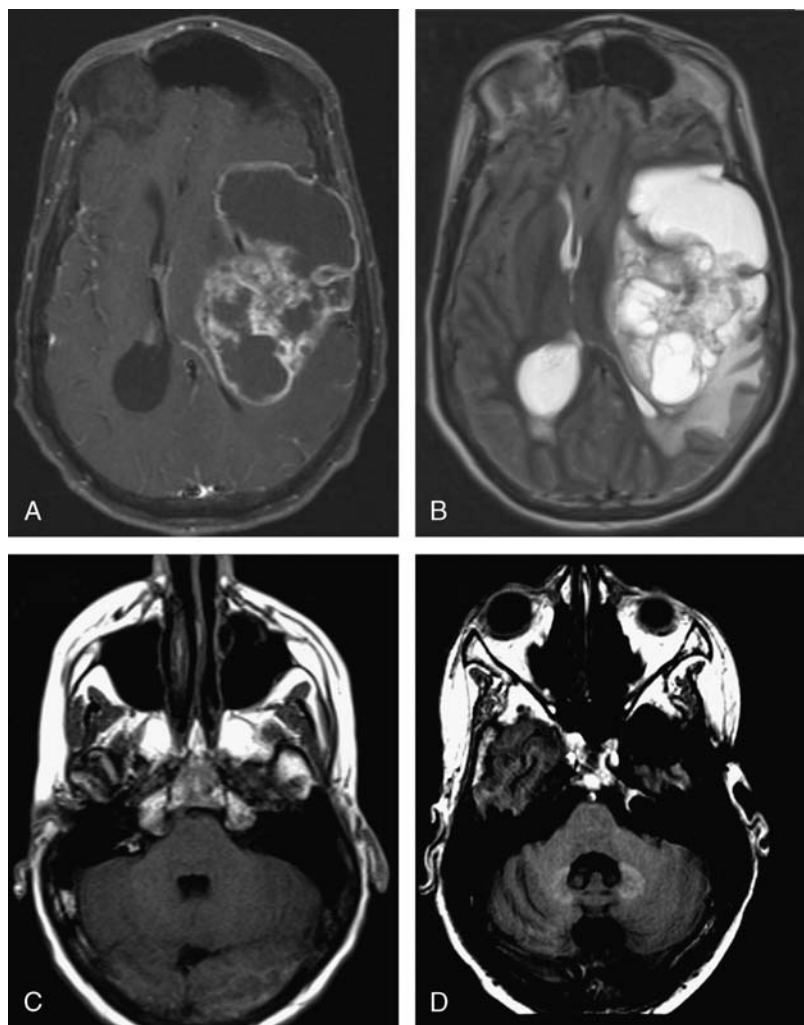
Axial postcontrast, fat-saturated, T1-weighted image (A) and axial T2-weighted image (B) through the brain demonstrated an aggressive appearing tumor involving the left temporal lobe with areas of necrosis and surrounding infiltrative edema. There was mass effect on the ventricular system and resultant hydrocephalus. Axial nonenhanced T1-weighted images through the cerebellum from the patient's initial magnetic resonance imaging (MRI) examination (C) and from the patient's 61st MRI examination (D) demonstrating the development of hyperintensity within the dentate nucleus are also shown.
